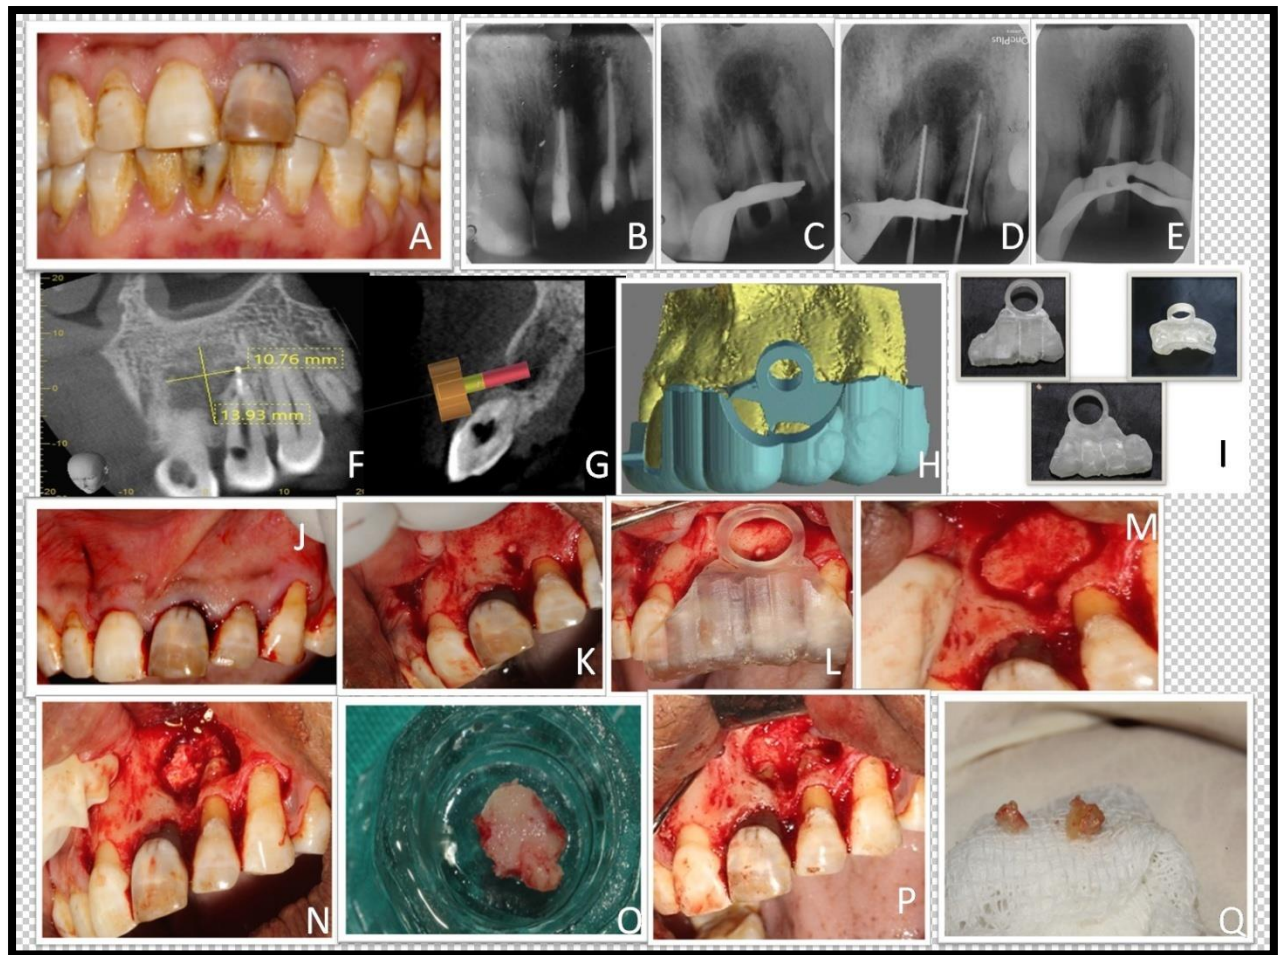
A) Pre-Operative photograph, B) Pre-Operative Radiograph, C) After guttapercha removal, D) Working Length Determination, E) MTA obturation, F) Marking of Lesion in CBCT, G) Designing for 3D model fabrication, H) CAD designing, I) 3D printed model with surgical guide, J) Crevicular with vertical releasing incision, K) Full thickness mucoperiosteal flap raised, L) Placement of 3D guided template, M) Marking of Buccal Cortical Plate, N) Infected tissue removal, O) Preservation of buccal cortical plate, P) Curettage, Q) Resected root ends.
